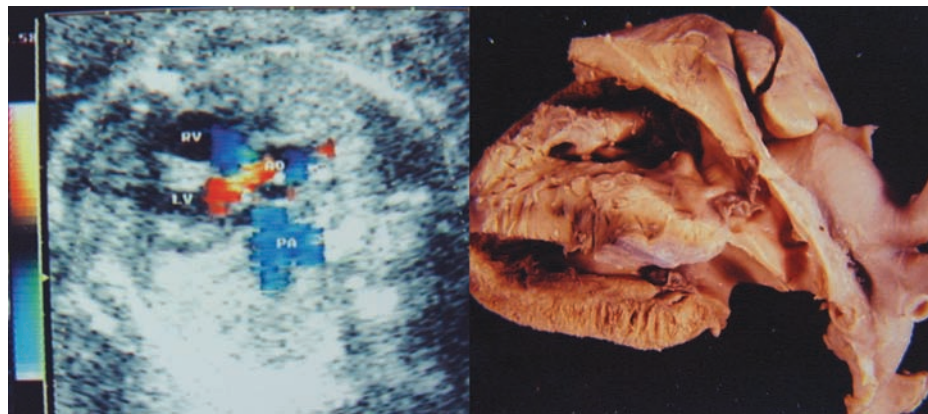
Normal longitudinal color flow Doppler cut at lateral dorsum. Crossing of the outflow tracts and arteries and anatomic correlation.
